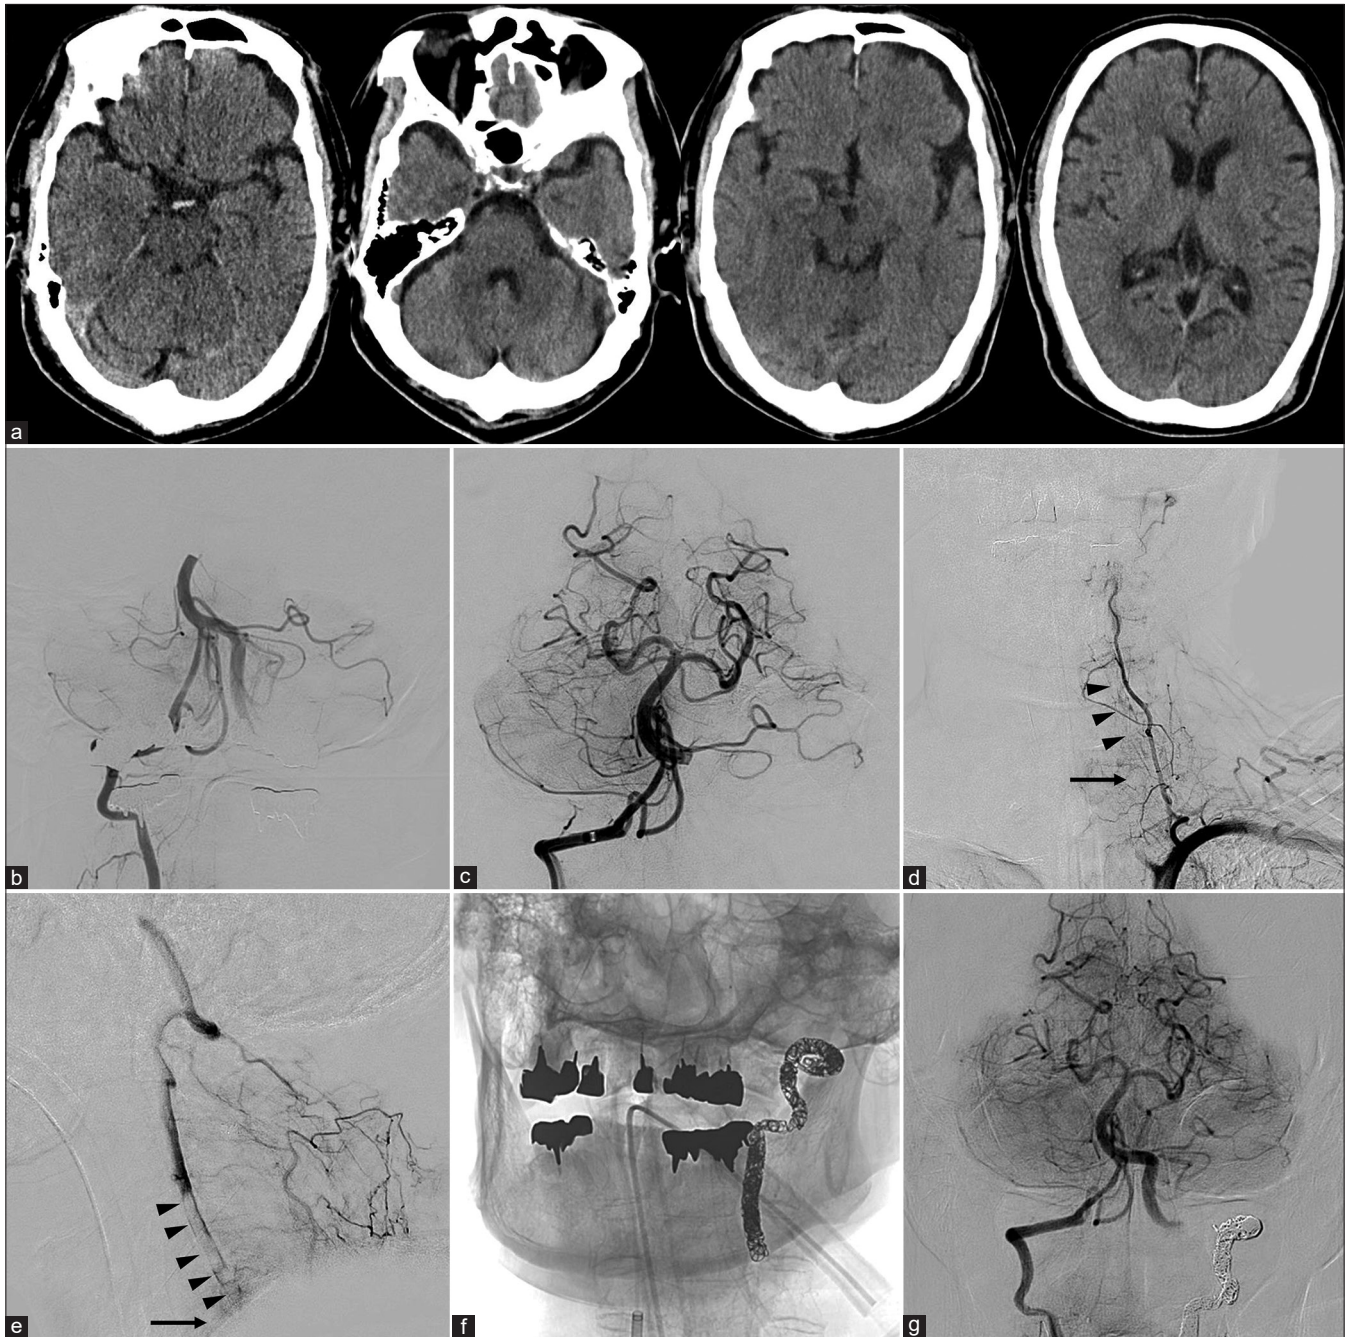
Preoperative and intraoperative images at our hospital: (a) preoperative head computed tomography (CT) shows a hyperdense sign at the tip of the basilar artery and hypodense areas in the left cerebellum and midbrain (posterior circulation acute stroke prognosis early CT score 7 points). (b) Before thrombectomy, right vertebral artery angiography shows occlusion at the tip of the basilar artery. (c) After thrombectomy, right vertebral artery angiography shows complete recanalization of the tip of the basilar artery. (d and e) Left subclavian artery angiography shows occlusion at the origin of the left vertebral artery. Collateral blood flow from the left deep cervical artery to the left vertebral artery is observed, with anterograde flow beyond the level of the 6th cervical vertebra (arrow). Thrombi (arrowheads) are seen within the left vertebral artery at the level of the 4th–6th cervical vertebrae. (f) Coil embolization was performed in the distal part of the left vertebral artery from the level of the 3rd/4th cervical vertebra to the V3 segment. (g) After coil embolization, right vertebral artery angiography shows retrograde blood flow of the left posterior inferior cerebellar artery through the left vertebral artery.
